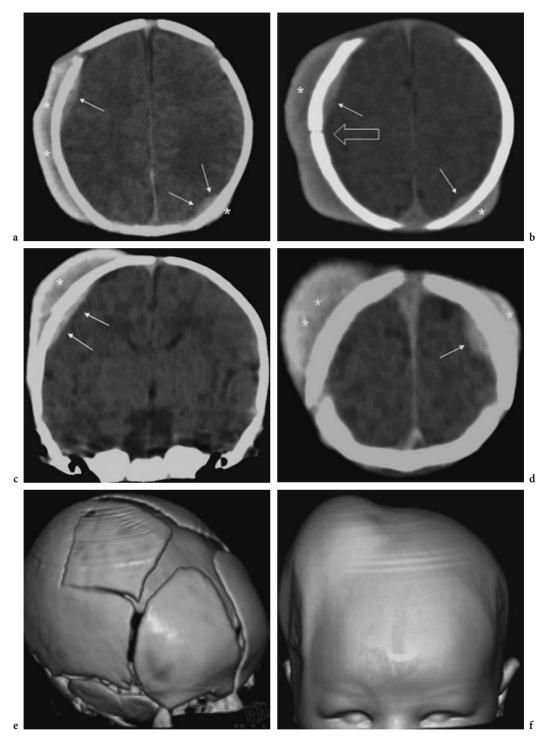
Male newborn with gradual soft-tissue swelling on the right side of the head after difficult delivery assisted with vacuum extractor. Standard skull X-ray showed linear parietal fracture. A 6-MDCT helical brain exam was performed with adapted paediatric protocol: 110 kV, 125 mAs, 1 s rotation, CTDI vol of 23.75 mGy, pitch factor of 1. Calculated effective dose was 5.9 mSv. a, b Axial 5 mm images showing bilateral epidural haematomas (*arrows*), skull fracture (*open arrow*) and large (right) and small (left) cephalhaematomas (*asterisks*). c, d A 5 mm coronal MPR image and 5 mm axial image showing communication of the right epidural haematoma with right cephalhaematoma trough skull fracture (*open arrow*); there is no brain oedema or important mass effect of the hematomas. e, f Volume rendering images with bone setting (e) show the extent of the linear, angle-shaped right parietal bone fracture and with soft-tissue settings (f) show nicely the extent of the cephalhaematomas
